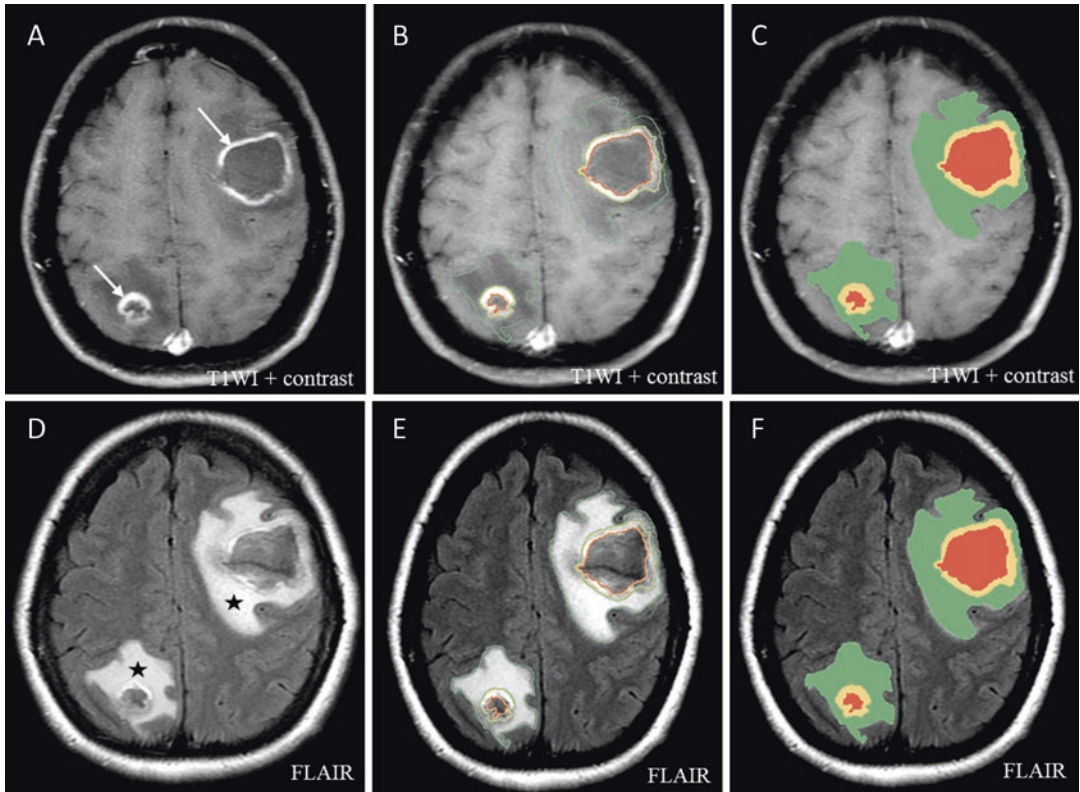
Axial plane MRI, T1WI with contrast (a, b, c) shows the 2 peripherally enhancing tumors (arrows on a) better than the CT on Fig.4.1. Additionally the 3 components of the tumor can be separated with color-coded labels to *edema*, *solid tumor*, and *central necrosis*, creating the radiophenotypes (overlapped on b and c) that can then be used for feature analysis and indirectly obtain
